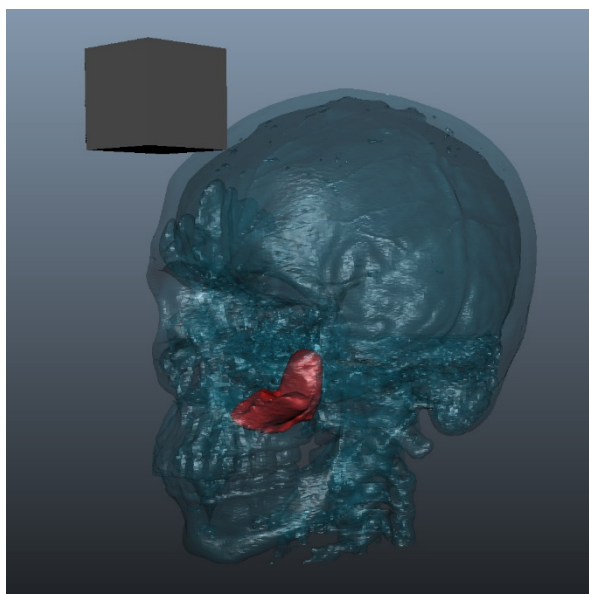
Left image - A constructed model of the face and skull based on CT data; in the middle are designated areas for fixing the frame, on the right is the model of the frame with a zone for the marker on top.
